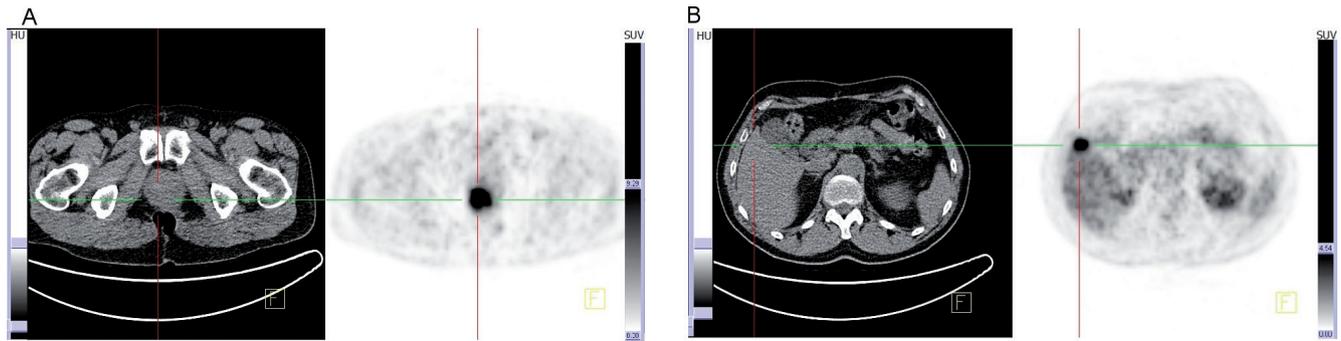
(A) CT and PET image showing local recurrence of rectal cancer in 55 year-old male patient (CEA 6 ng/ml; CA 19-9 97 U/ml); (B) CT and PET image of liver metastasis of CRC in 57 year-old male patient with elevated CEA (50 ng/ml) and normal CA 19-9
